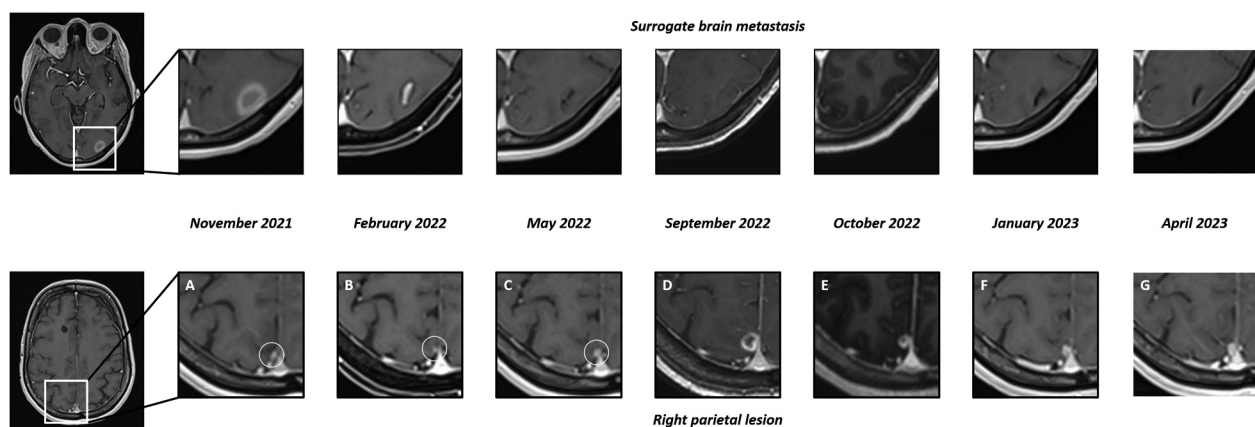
MRI showing a brain metastasis selected as a surrogate of the systemic disease and the right parietal lesion. A complete response was reached in all other brain and systemic lesions at the time of the third MRI (9 months after ICI discontinuation), as demonstrated by the evolution of the surrogate brain lesion.
